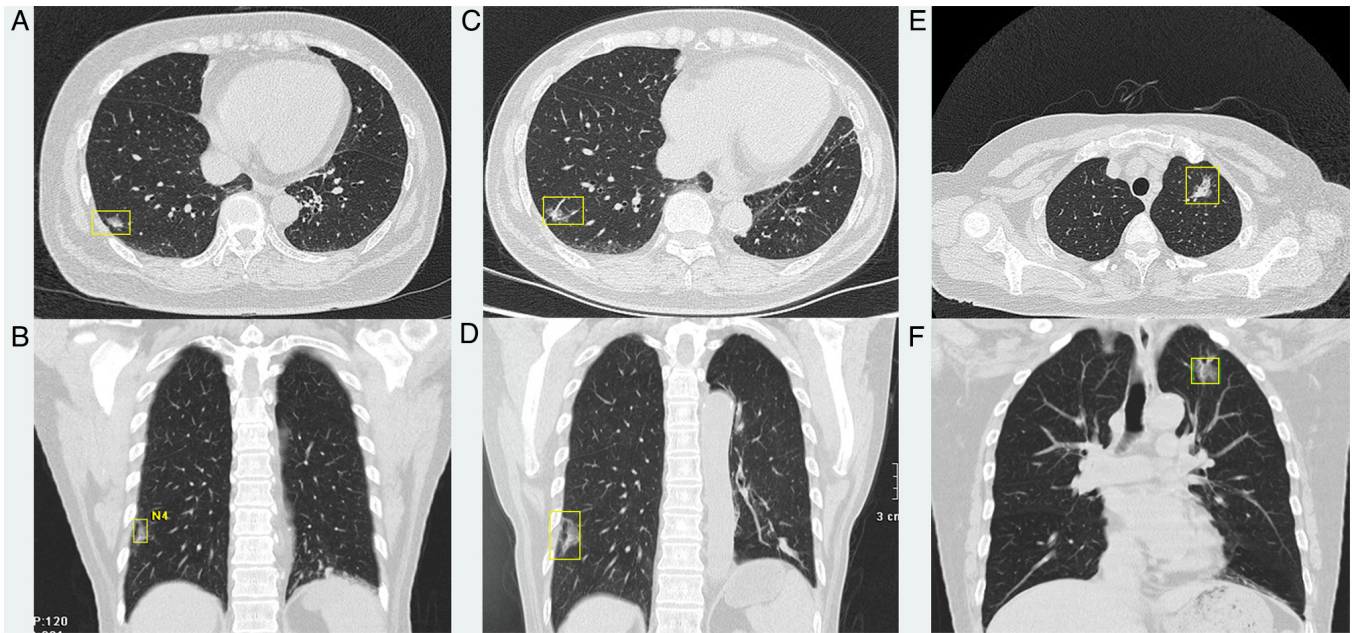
Chest computed tomography scan. (A and B) Partially solid nodule in the lateral basal segment of the lower lobe of the right lung, observed in July 2021. (C and D) Partially solid nodule in the lateral basal segment of the lower lobe of the right lung, observed in April 2024. (E and F) Partially solid nodules in the apical and posterior segments of the left upper lobe, observed in July 2021.
